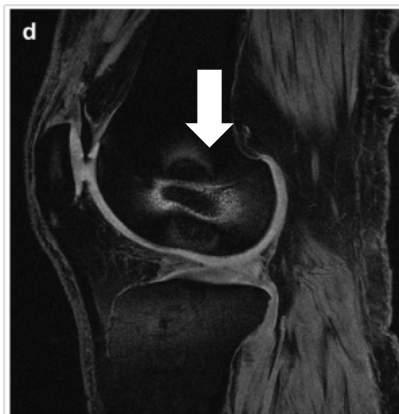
MRI interference cause by a titanium interference screw used for ACL reconstruction. (Source: Bowers et al., 2008)
